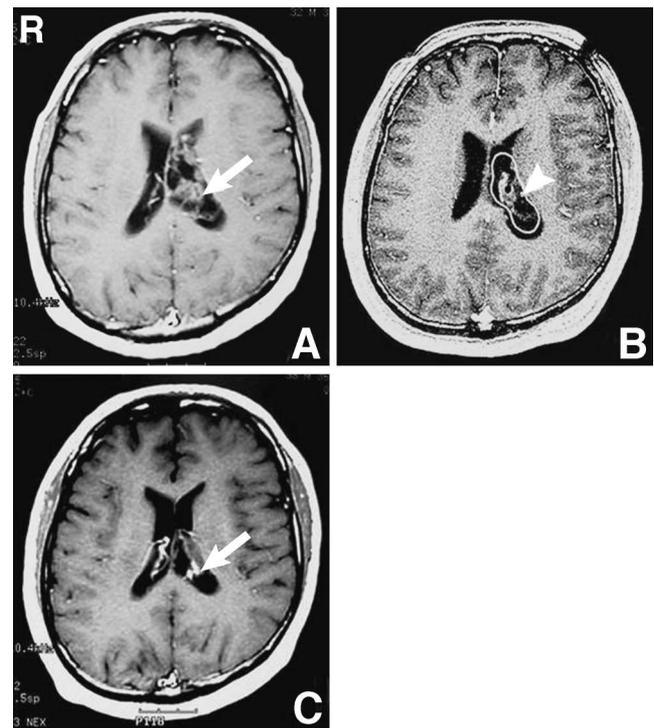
Case 1. Axial T₁-weighted magnetic resonance images with gadolinium enhancement, (A) on admission revealing a slightly enhanced mass in the left lateral ventricle without hydrocephalus (arrow), (B) after incomplete surgical excision showing the radiosurgical plan for the residual tumor (arrowhead), and (C) 49 months after gamma knife radiosurgery showing shrinkage of the residual tumor (arrow).
